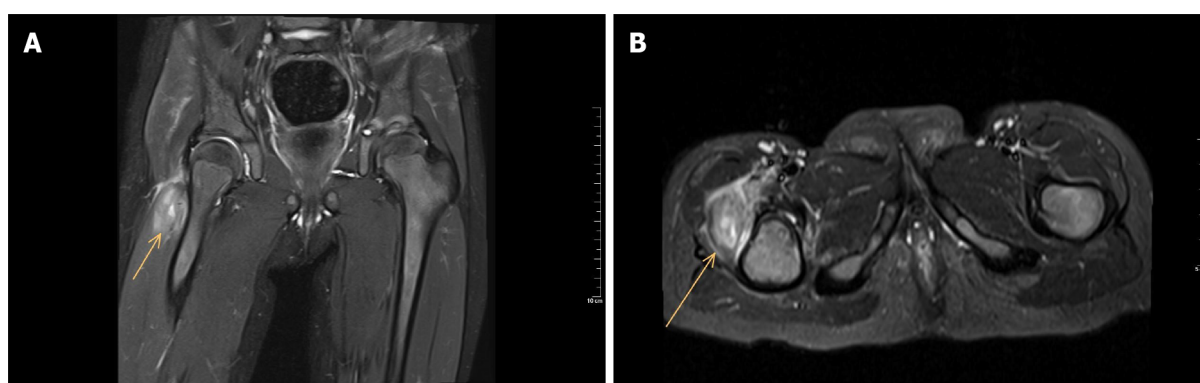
T2 magnetic resonance imaging of a three-year-old girl with pyomyositis of the vastus lateralis at the right side (arrow). There is no excessive fluid in the hip joint space. A: Coronal view; B: Sagittal view.
